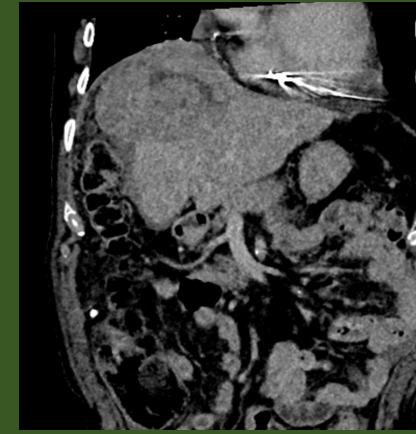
Coronal CT image of target hepatocellular carcinoma
